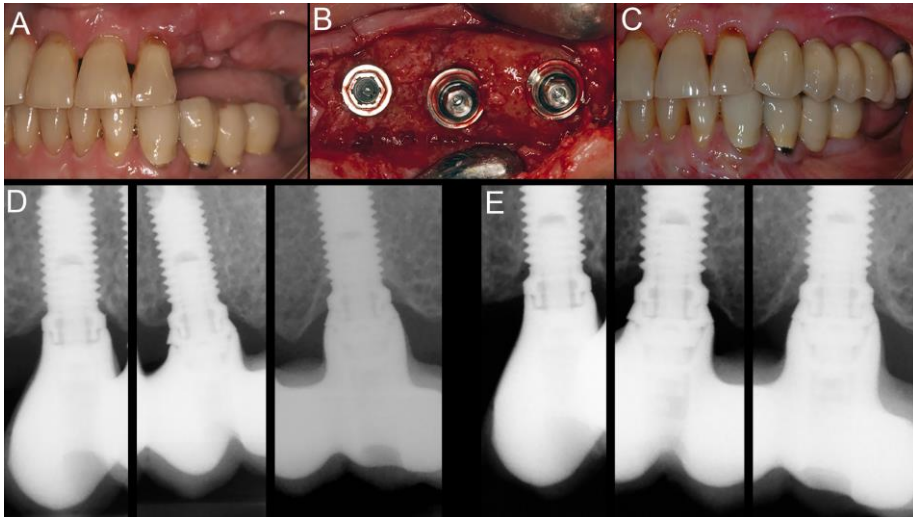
Clinical and radiographic images from a test patient. A) Pre-operative view. B) Three implants placed in the left maxilla. C) Permanent fixed prosthesis placed 6 months after surgery. D) Intra-oral radiographs at 1-year follow-up. E) Intra-oral radiographs at 5-year follow-up.
